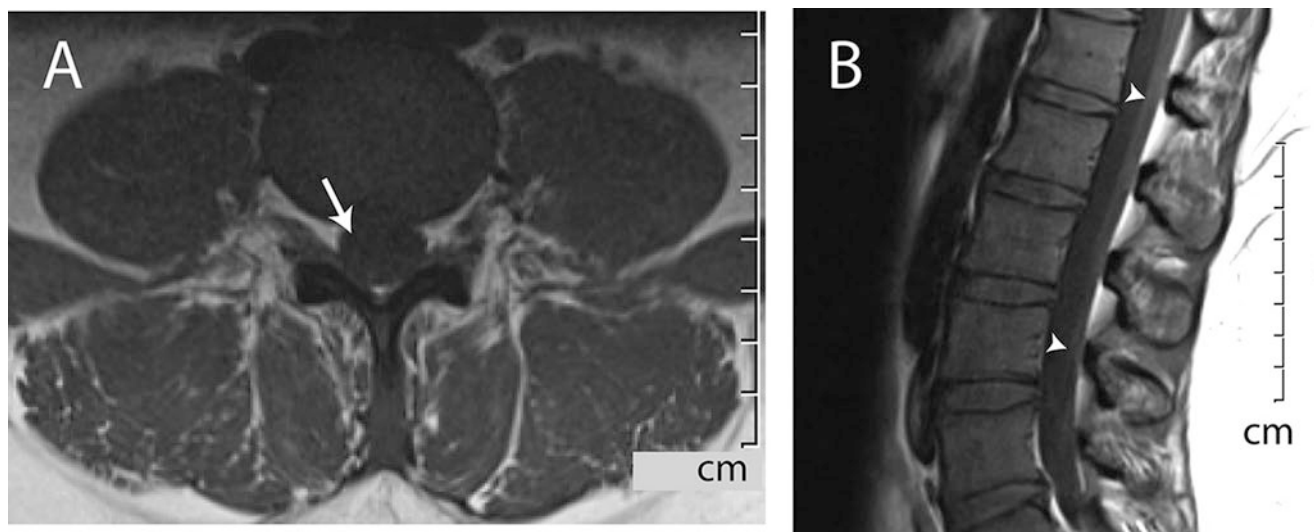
Normal T1-weighted MRIs. (a) In the axial plane through a lumbar disc (*anterior up*). (b) In the midline sagittal plane of normal lumbar vertebrae (*anterior left*). Fat has a high signal intensity (appears bright), whereas muscle and disc have intermediate signal intensity. Low signal intensity (*dark*) is characteristic of water (e.g., CSF, *straight*
